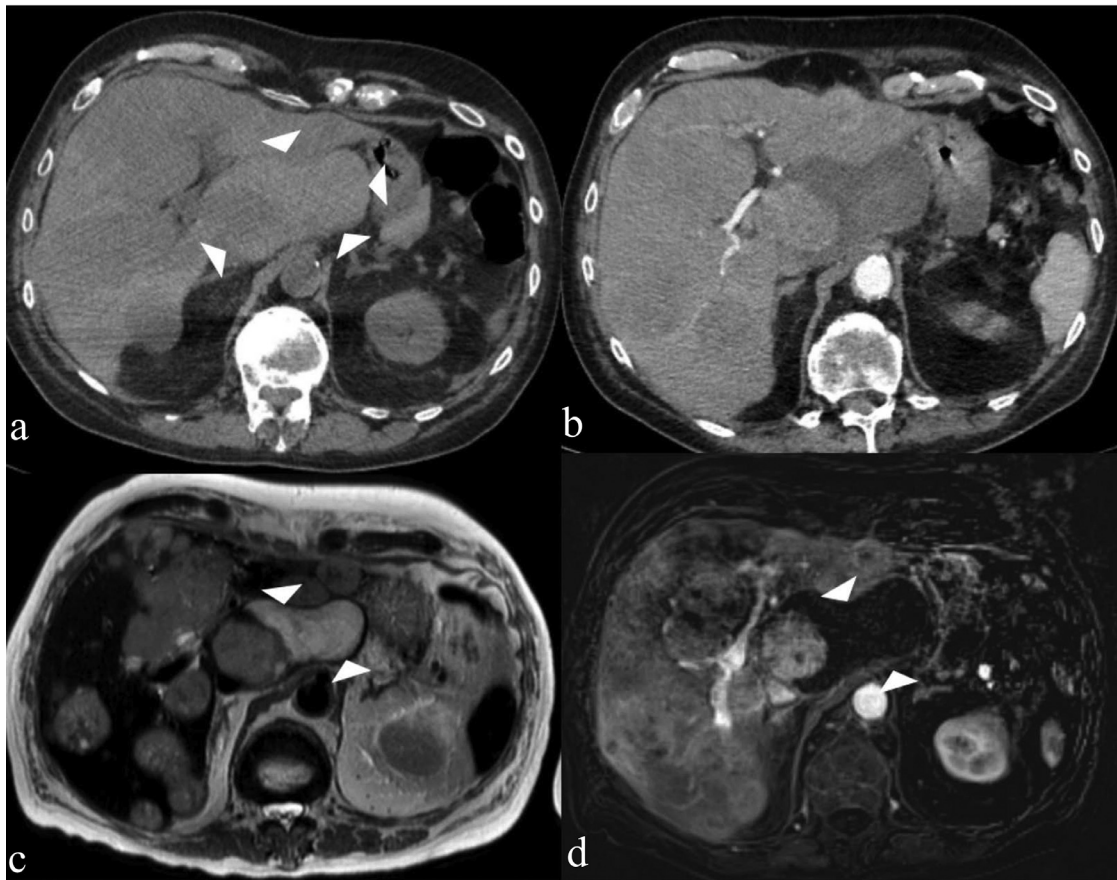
(A) Axial noncontrast-enhanced CT image shows hyperdense hematoma with no progression in size (B) Axial contrast-enhanced CT image shows no active extravasation. Axial T2W image (C) and postcontrast T1W image (D) show no progression in size of both caudate lobe metastases and hematoma.
